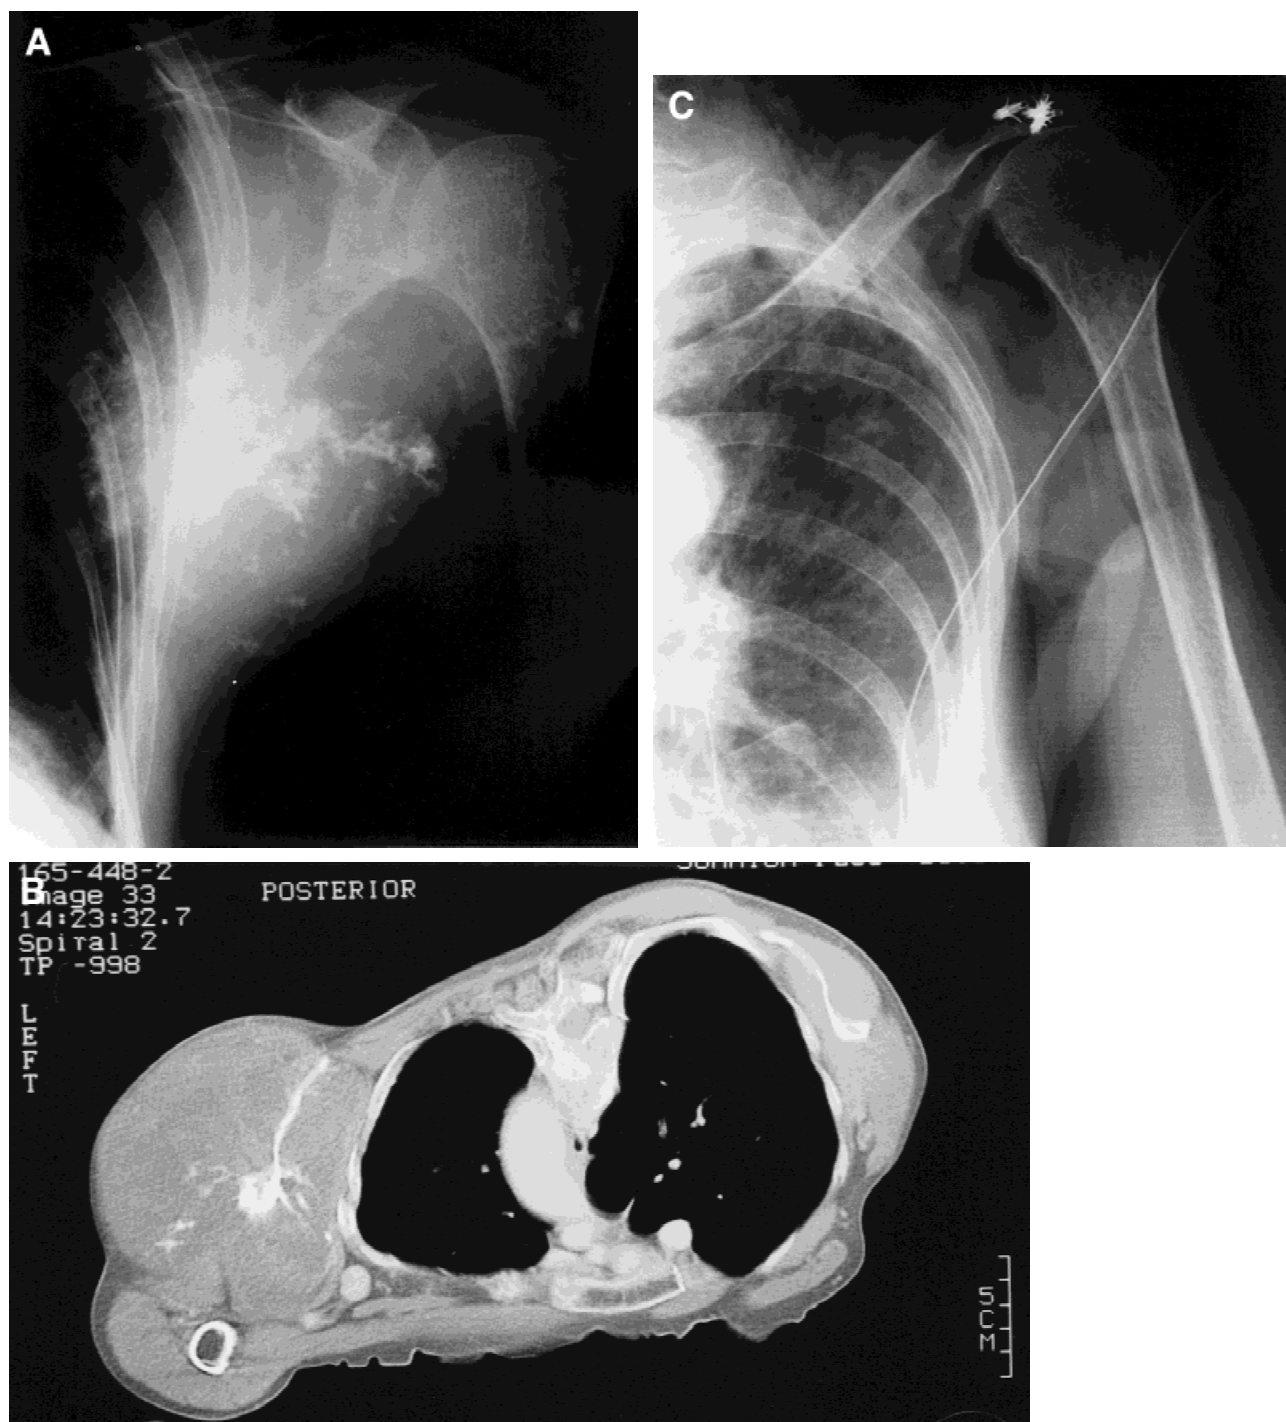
Case 9. A: Preoperative radiograph of chondrosarcoma involving the entire scapula. B: Computed tomographic scan. C: Postoperative radiograph. In this case, an anchor system was used for augmentation of soft-tissue reattachment to the clavicle.
